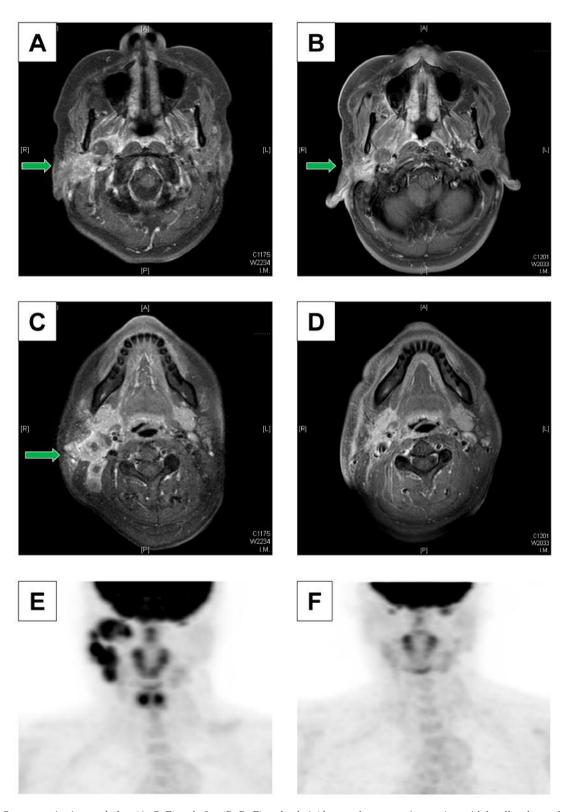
Representative images before (A, C, E) and after (B, D, F) carboplatin/docetaxel treatment in a patient with locally advanced, androgen receptor-negative salivary duct carcinoma. Post-treatment magnetic resonance imaging scans revealed a partial response of the right salivary gland tumors and the right cervical lymph node metastases. A fluorodeoxyglucose (FDG)-positron emission tomography scan after three cycles of therapy revealed disease resolution. The green arrows indicate the primary lesion (A, B) and multiple cervical lymph node metastases (C).
